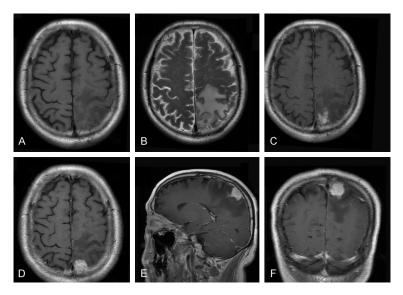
(A, B) Axial T1-weighted MRI reveals a 15*17*15 mm isointense mass on T1-weighed images and hypointense on T2-weighed images in the left parietal region. (C, D) Axial, (E) Sagittal and (F) Coronal enhanced T1-weighted MRI shows an inhomogeneous enhancing mass with obvious brain edema.
